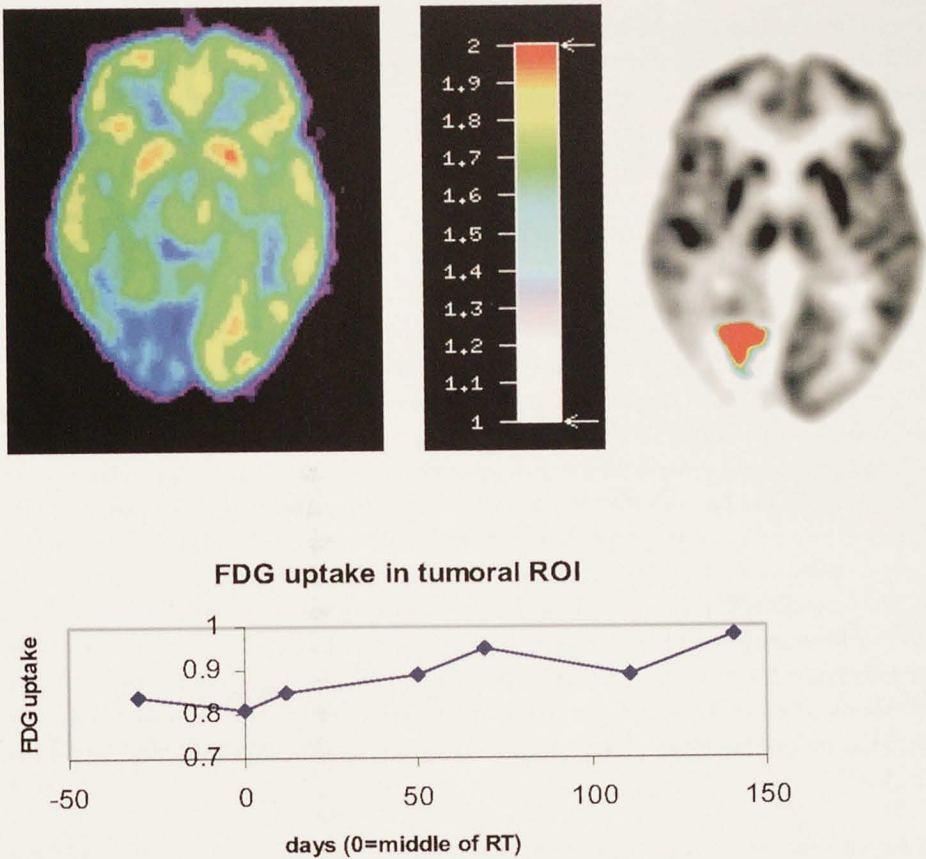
FDG PET shows FDG uptake in the surgical cavity (left top). Image demonstrating tumour recurrence by filling of the surgical cavity (middle and right top). Semi-quantitative ROI analysis suggesting tumour progression because of a slowly rising time regression curve (bottom).
